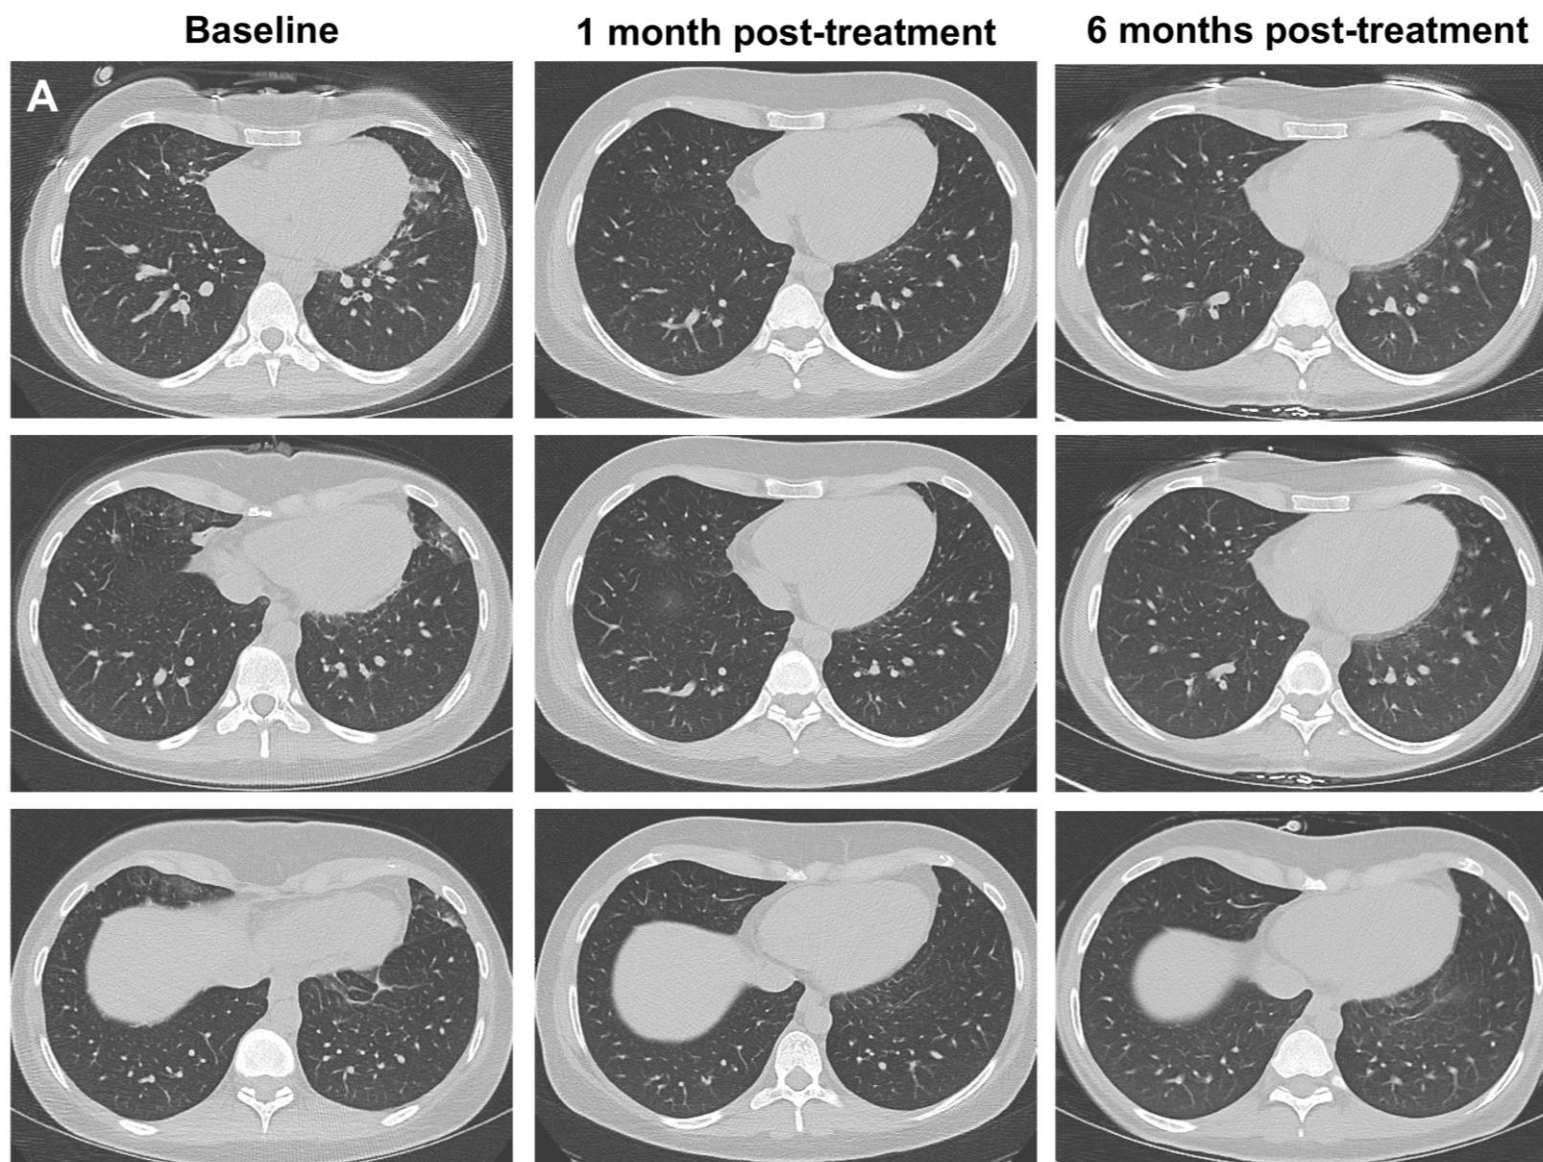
Treatment response assessed by radiography in patient 3. Shown are serial axial (A) and coronal (B) chest CT images and coronal 3D reconstructed CT images (C) at baseline and at 1 and 6 months after treatment initiation.
